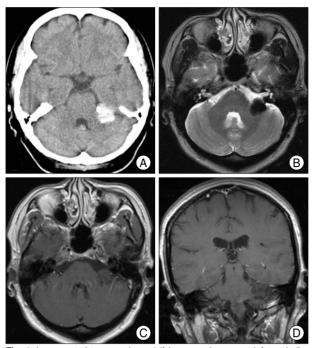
In computed tomography, calcifying mass is seen at left cerebellopontine angle region (A) and T2-weighted magnetic resonance (MR) image shows hypointense lesion on left cerebellopontine angle (CPA) (B). The axial (C) and coronal (D) gadolinium enhancement MR images show isointense lesion with minimal enhancement on left CPA and there is no dural enhancement or internal auditory involvement of the tumor.
